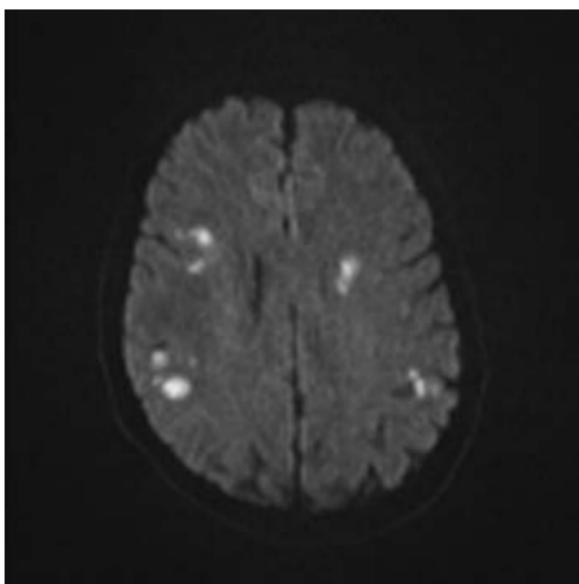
(c) and (d) Restriction of diffusion with hyperintensity on DWI and hypointensity on ADC corresponds with an acute infarct (white arrows).
